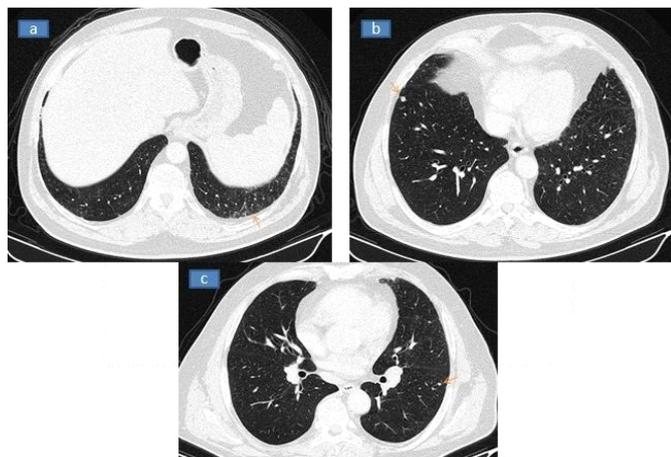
Chest CT scan. a. Interstitial thickening at the basal region of lower lobes (arrow). b, c. Non-specific, small pulmonary nodules with irregular distribution in upper and middle lobes bilaterally (arrows).
